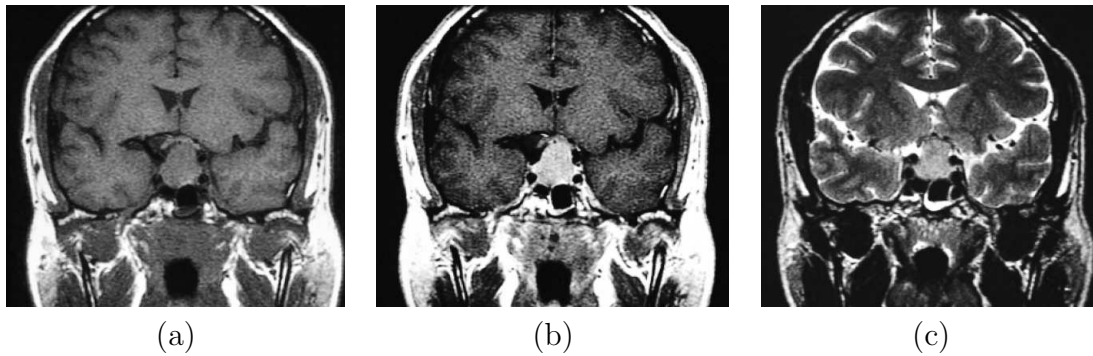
Pituitary adenoma. a) Coronal T1-weighted MRI showing a large pituitary macroadenoma. b) Coronal MRI showing the same tumor enhancing with contrast enhancement. c) T2-weighted image of the same patient [Emedicine, 2005].
